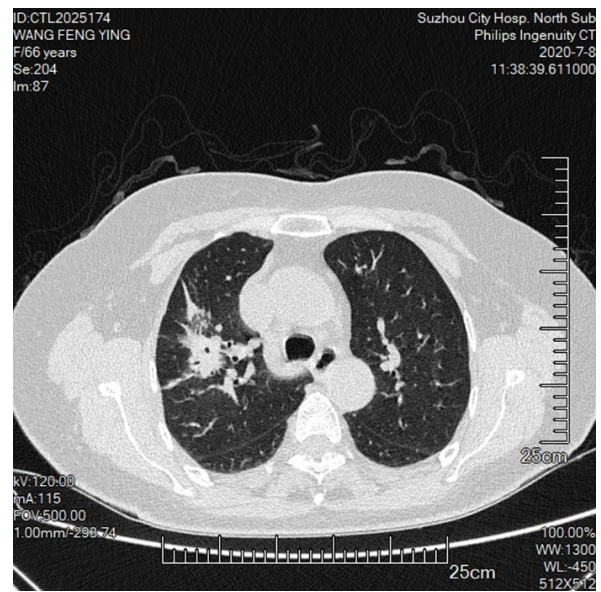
34 cases were cavitation signs which were indicated by CT.
